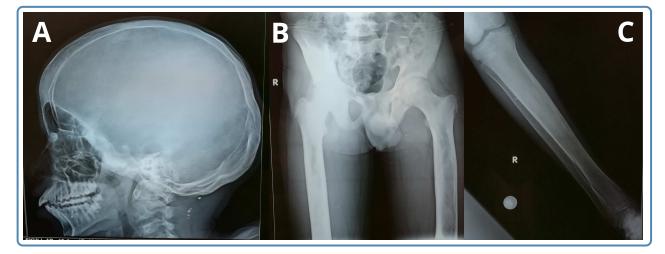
Skeletal radiographs of the patient. A. Lateral view of the skull showing the widening of the diploic spaces and sclerosis of the base of the skull. B. & C. Anteroposterior view of the pelvis, both femurs and the right tibia & fibula showing the increased bone density, diaphyseal widening and cortical hyperostosis.
